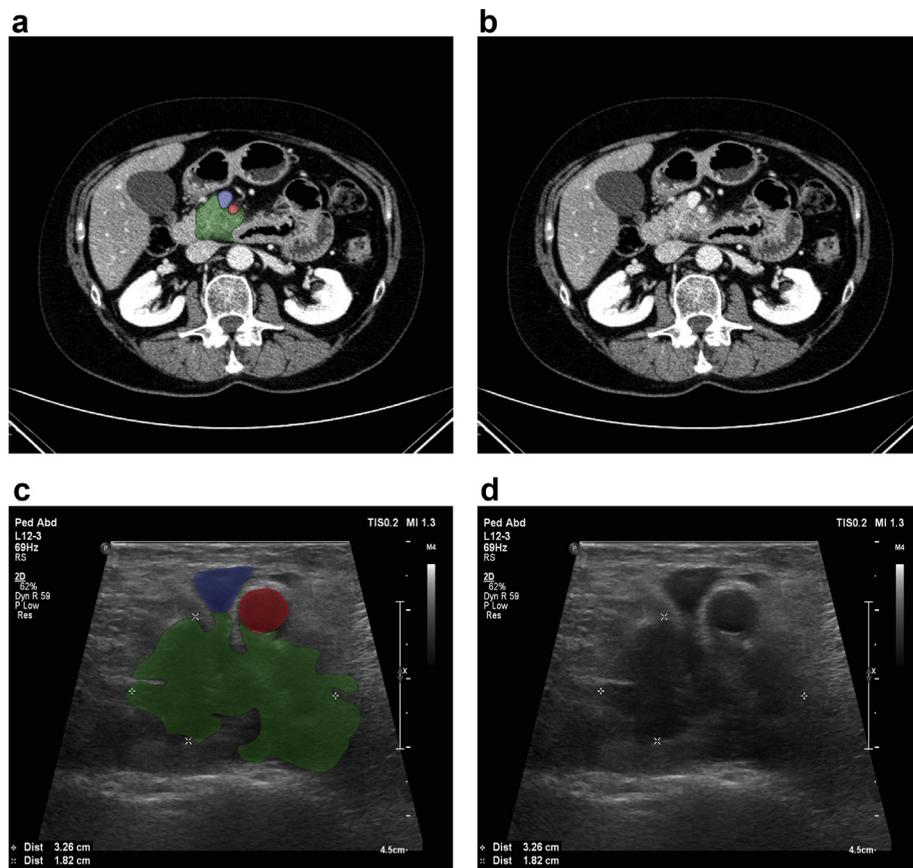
Pre-operative CT-scan and IOUS in a patient with pancreatic cancer after 4 cycles of FOLFIRINOX. (a, b) Upon CT-scan, 90–180° tumor infiltration (green) was seen around the superior mesenteric vein (blue) and 180–270° contact with the superior mesenteric artery (red), rendering this patient unresectable. (c, d) Upon IOUS less tumor infiltration was seen: <90° (green) around the superior mesenteric vein (blue) and 90–180° with the superior mesenteric artery (red), rendering this patient borderline resectable
